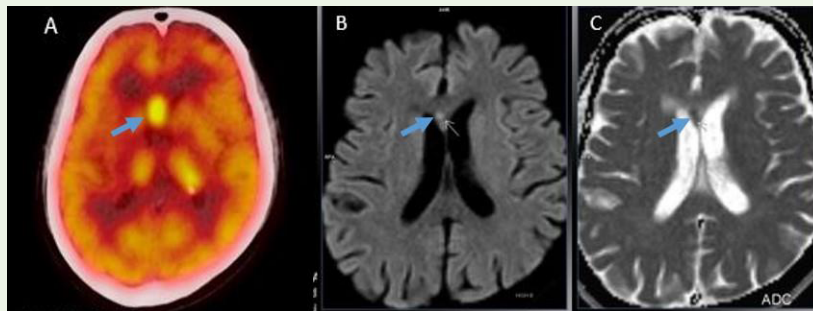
Image A: FDG PET-CT scan showing a hypermetabolic focus in the genu of corpus callosum. Image B and C: DWI demonstrating a lesion in the genu of corpus callosum with restricted diffusion.
